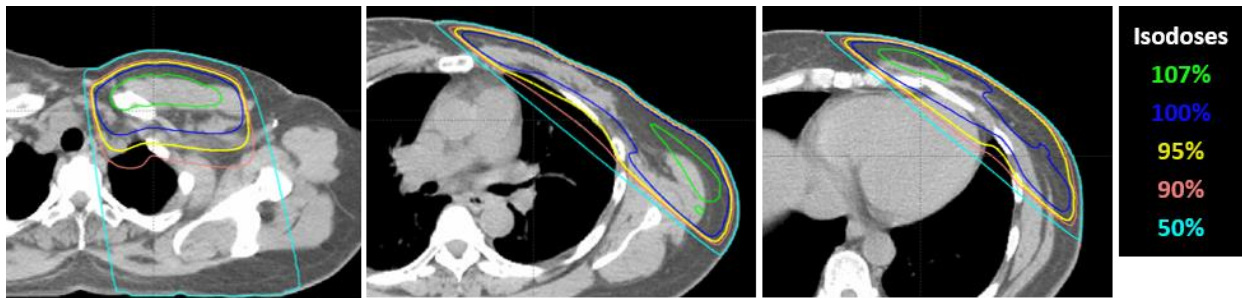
The resulting dose distribution for a test patient for whom the PMRT plan was rated use as is. The dose is shown on three different axial slices of the CT scan: in the supraclavicular field (left), in the superior half of the tangential fields (middle), and in the inferior half of the tangential fields (right).
